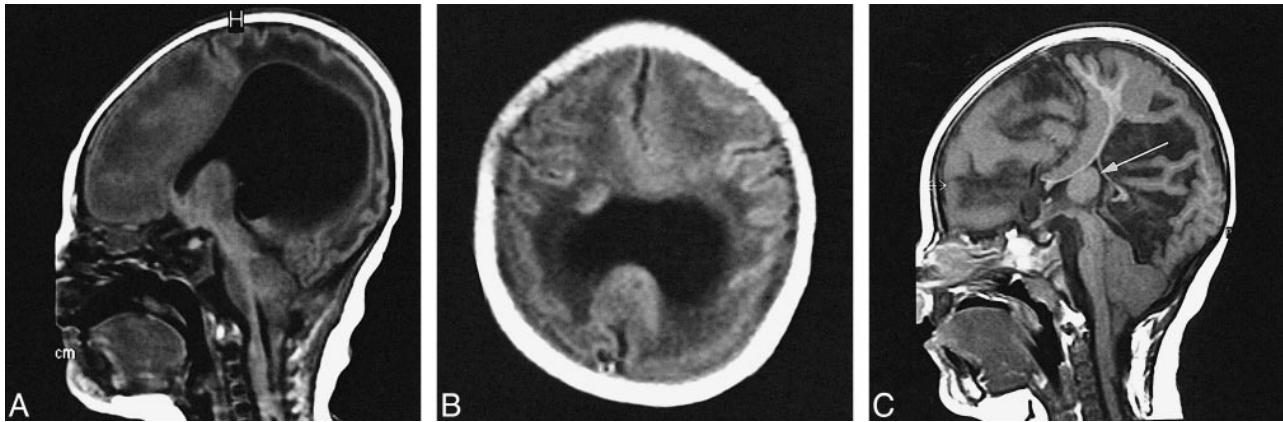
MR images from a case of coexistent Chiari II malformation and holoprosencephaly that occurred in a viable infant.
